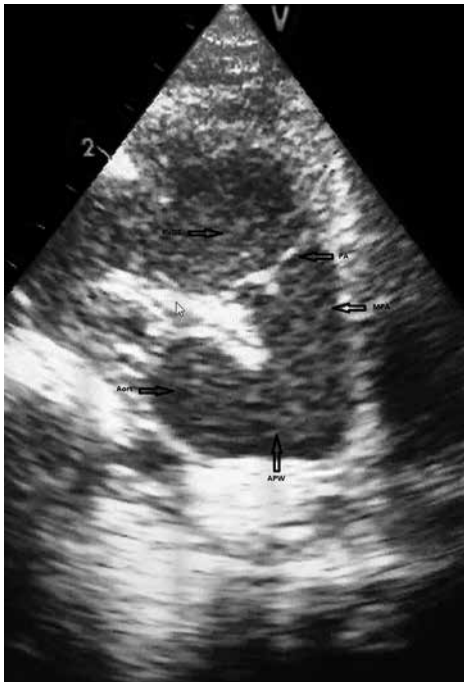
Aortopulmonary window showing in parasternal short axis image on transthoracic echocardiographic examination.
